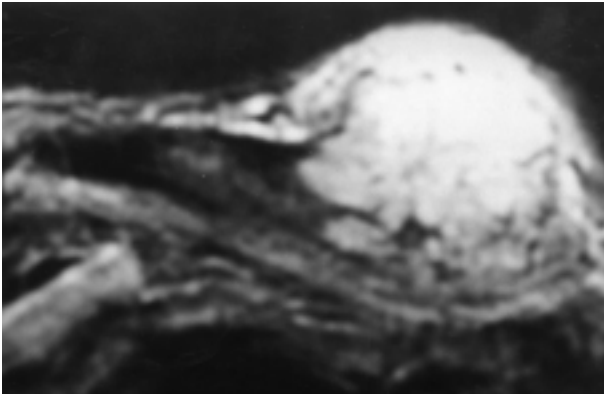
Patient 1*: Coronal- T2- MRI: Osteolytic lesion with a soft-tissue component close to the acromioclavicular joint.
